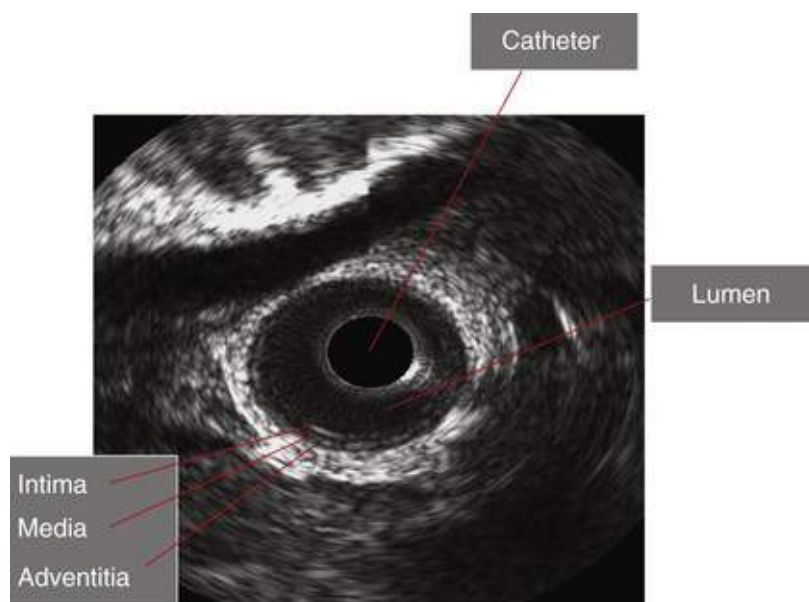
Normal vessel architecture on intravascular ultrasound (IVUS) demonstrating three layers: intima, media, and adventitia. (Courtesy Dr. Annapoorna Kini, Icahn School of Medicine at Mount Sinai, New York.)
